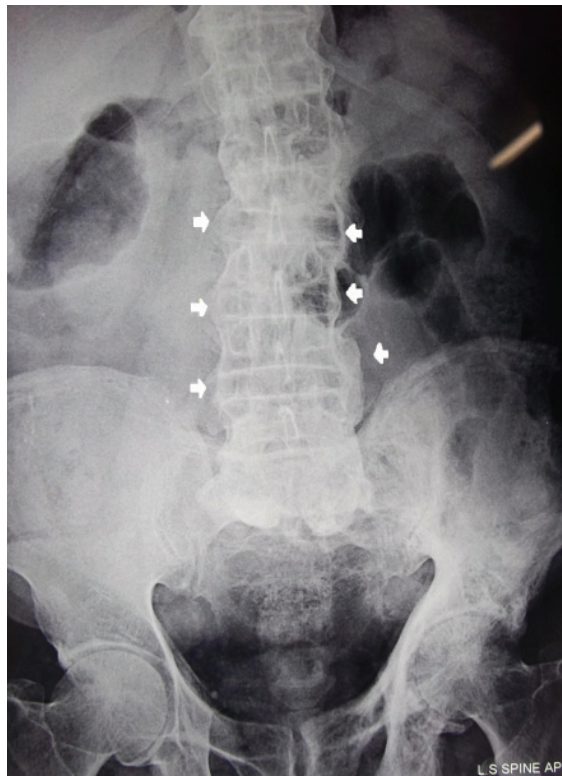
X-Ray L-S spine A-P view. Arrows show flowing osteophytes and soft tissue ligamentous calcification.
